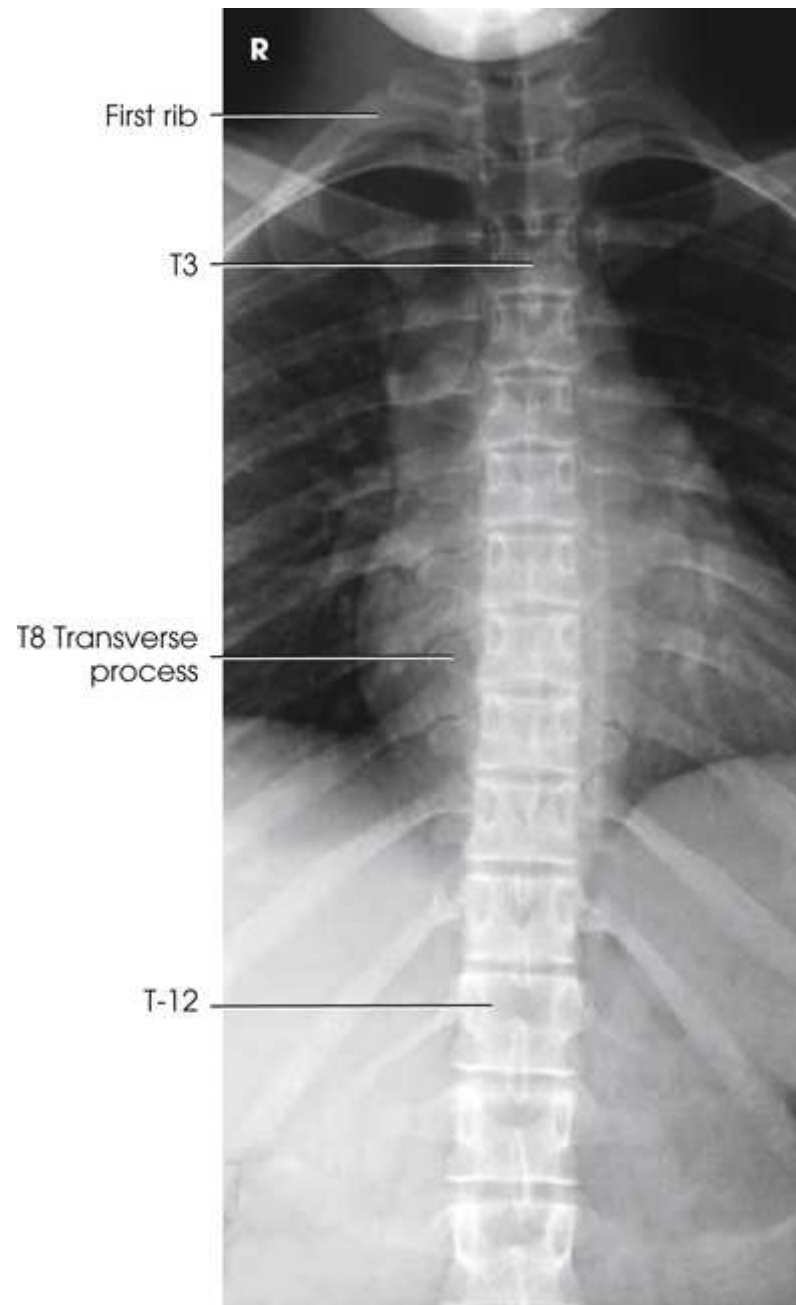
Cathode end of x-ray tube over lower thorax (more uniform exposure).
